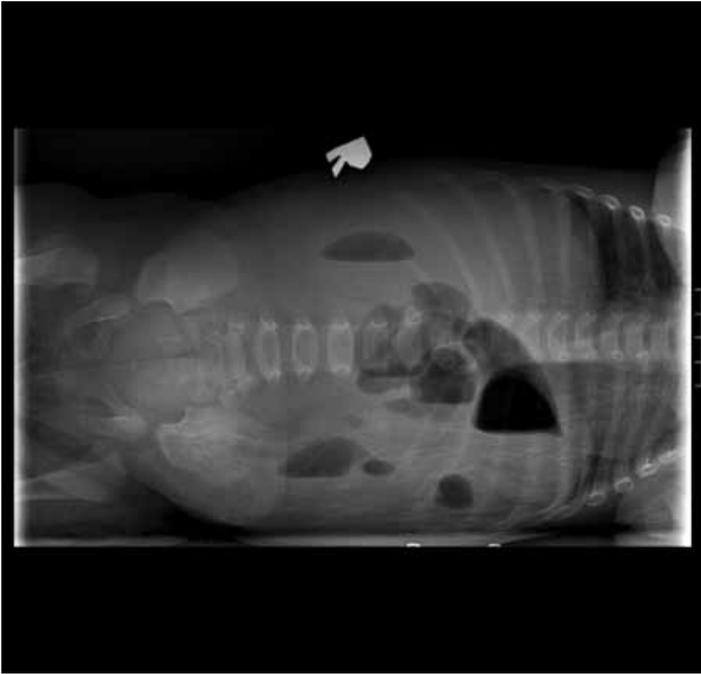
Intussusception. Lateral abdominal Xray: air-fluid levels (intravascular volume status impacted) and no obvious perforation (non-specific)
